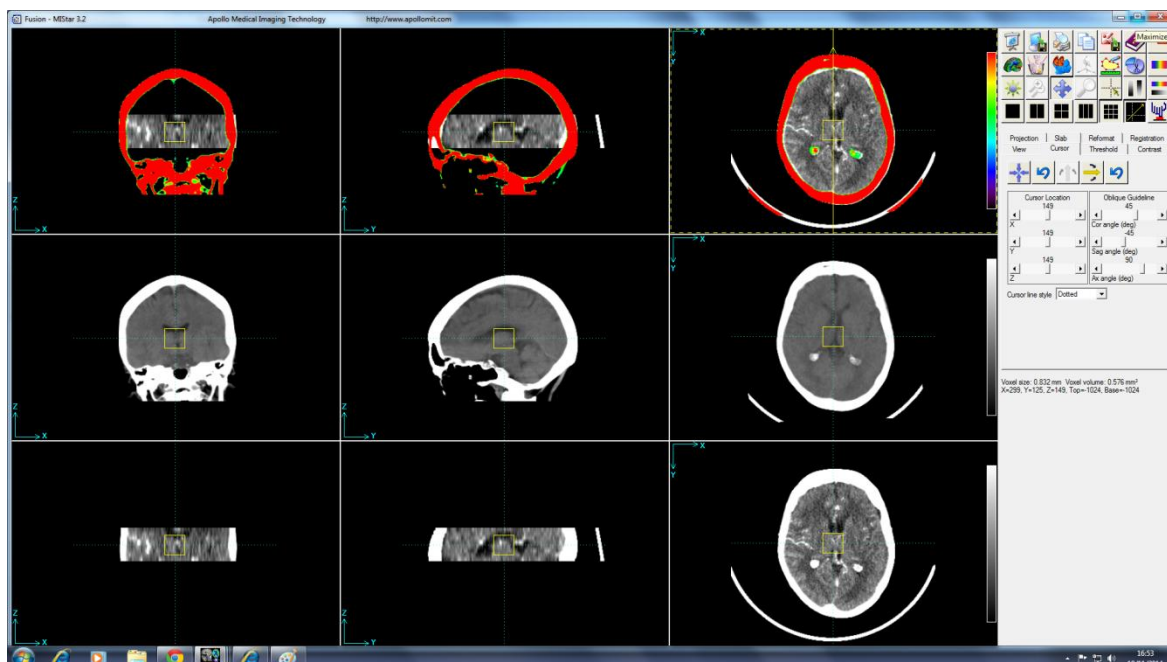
CTP, CT Coregistration- step 2
